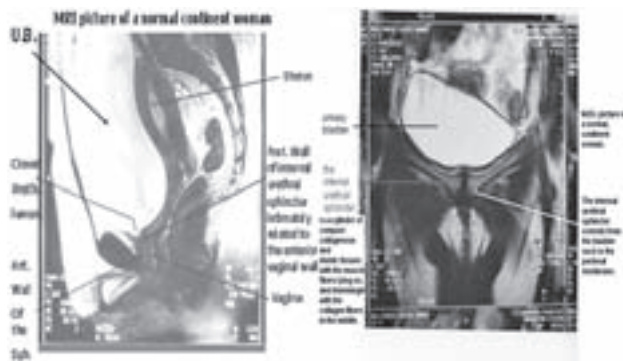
MRI pictures. Sagittal, and coronal sections showing intact and strong internal sphincters as cylinders extending from the urinary bladder neck to the urogenital diaphragm. MRI picture of a normal continent woman. Although the urinary bladder is extremely full, the internal urethral sphincter is closing the urethra. The internal urethra sphincter (IUS) is seen intimately related to the tough and strong anterior vaginal wall.
